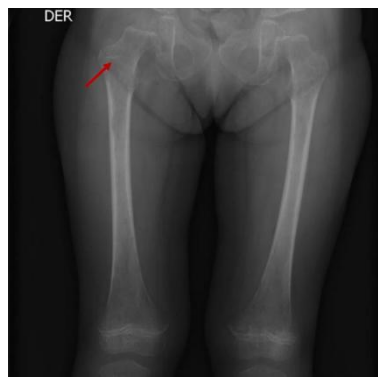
X-ray of long bones (femur), showing diffuse and heterogeneous changes in the visualized bone structures with patchy radiolucent areas predominantly in the metaphyses of the femurs. Source: prepared by the authors
